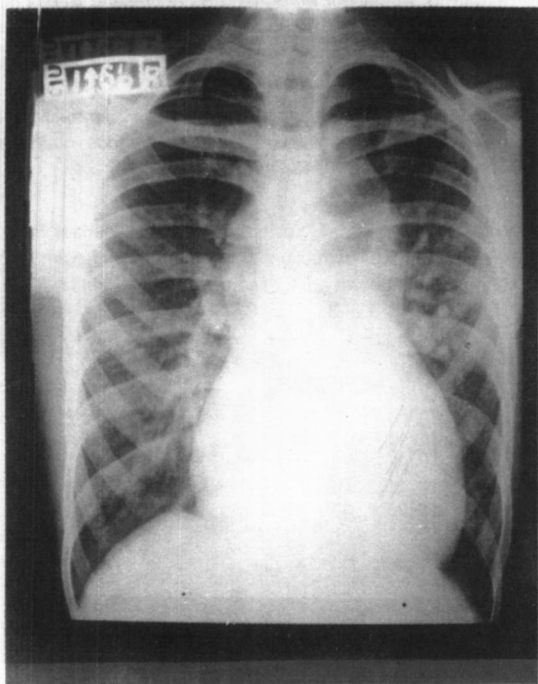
Chest X-ray showing the 'figure of 8', or 'snowman' appearance.
